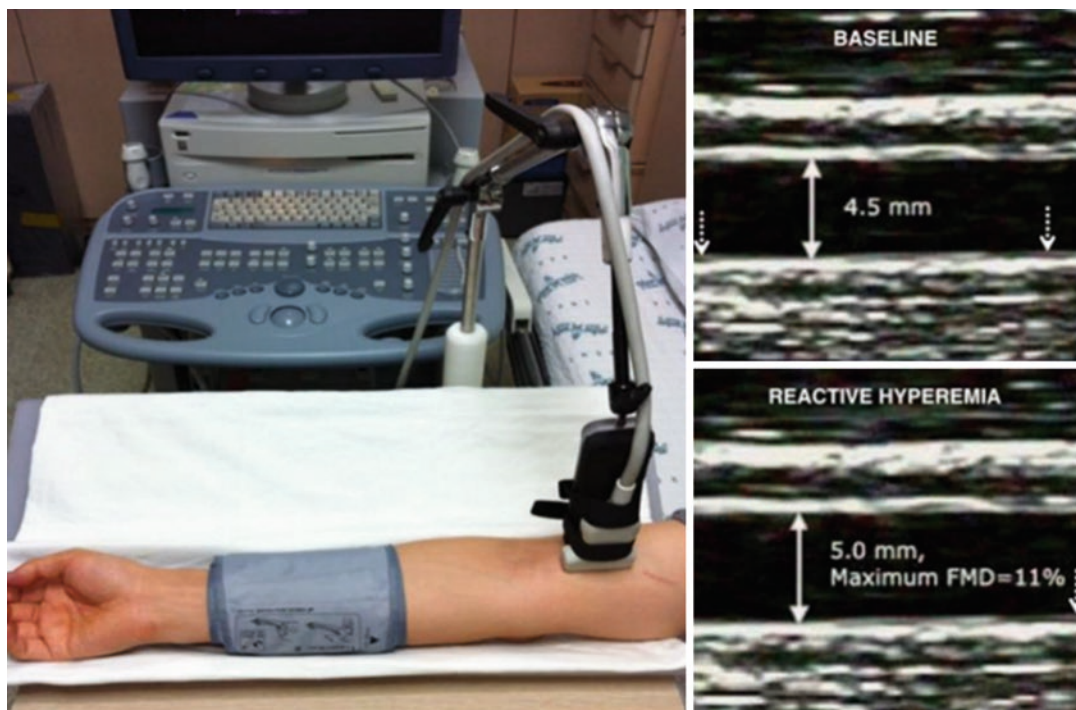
Standard FMD examination with cuff inflated around distal forearm and linear ultrasound probe held over brachial artery in longitudinal view.
